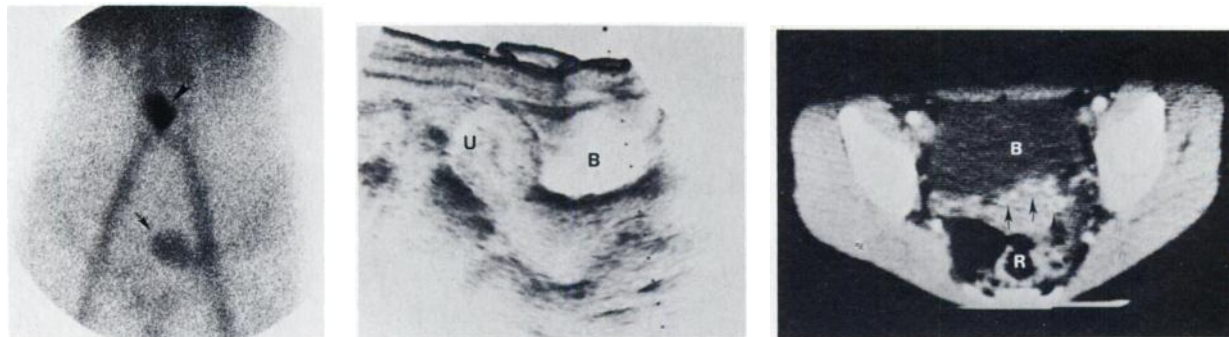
Scintigram made immediately after injection of pertechnetate (Tc-99m) (left). Intense early activity presents in uterus (arrow) during blood-pool phase. Arrowhead is umbilical marker. Longitudinal sonogram through area of increased activity demonstrates normal uterus (center). U = uterus; B = bladder. Transverse pelvic TCT scan through area of increased activity seen on Meckel's scan (right). Flow study demonstrates large uterine vessels (arrow). B = bladder; R = rectum.
